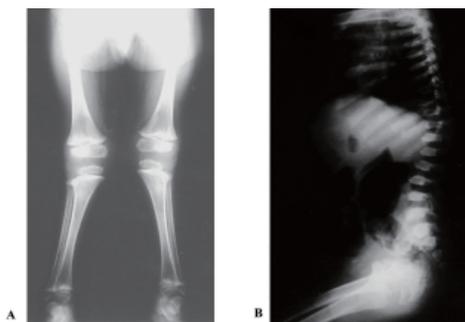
Radiological findings in case 18. X-ray of long bones of lower limbs showing genu valgus and broad metaphyses (A). Lateral view of thoracolumbar vertebrae and pelvis showing platyspondyly with increased joint spaces, shortening and broadening of femoral neck and fragmentation of greater and lesser trochanters (B).
